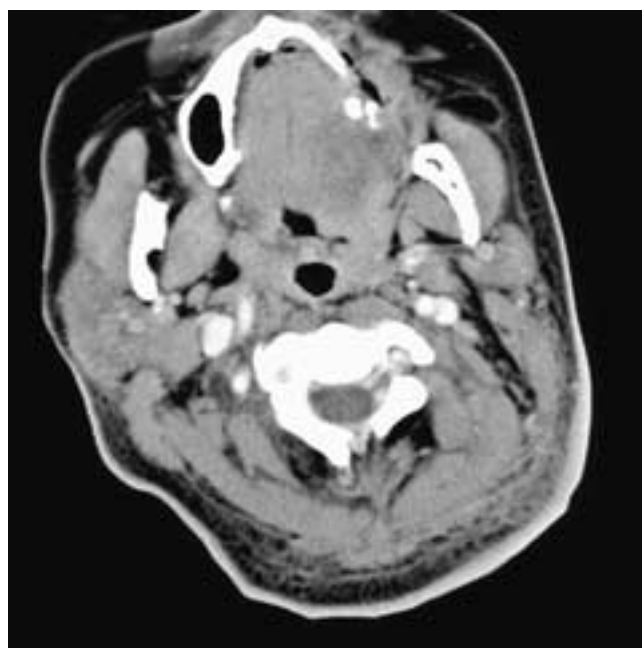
Axial contrast-enhanced CT scan shows marked thickening of the skin and subcutaneous tissues of the left posterior neck, all secondary to a cellulitis from a skin infection.
